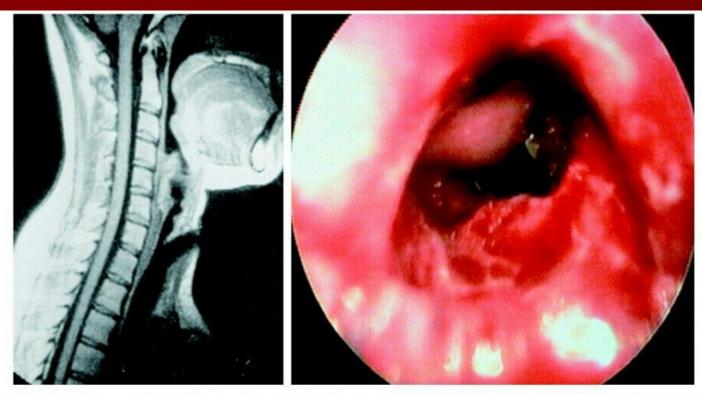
Subglottic stenosis in a patient with granulomatosis with polyangiitis. MRI (left) and endoscopic view (right). (Courtesy Dr. G. Hoffman. From Hoffman GS, Kerr GS, Leavitt RY, et al: Wegener granulomatosis: an analysis of 158 patients. Ann Intern Med 116:488–498, 1992.)
